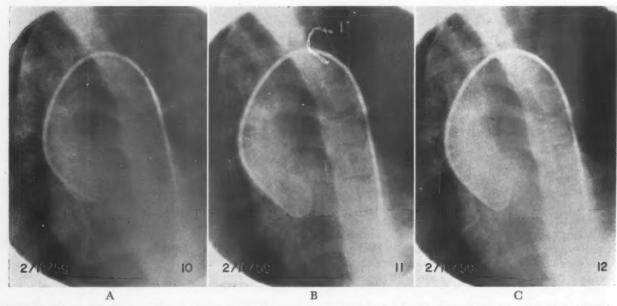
Three exposures taken during retrograde aortography, being the tenth, eleventh and twelfth in serial radiography at three exposures per second. A, exposure 10. Catheter tip of sinus of Valsalva with early filling of aorta and massive regurgitation into the left ventricle. B, exposure 11. Aorta is well filled with contrast dye outlining cusps. Opacification of aorta and left ventricle. C, exposure 12. Further delineation of aorta from cusps to the arch including great vessels; left ventricle well filled; no filling of right ventricle.
